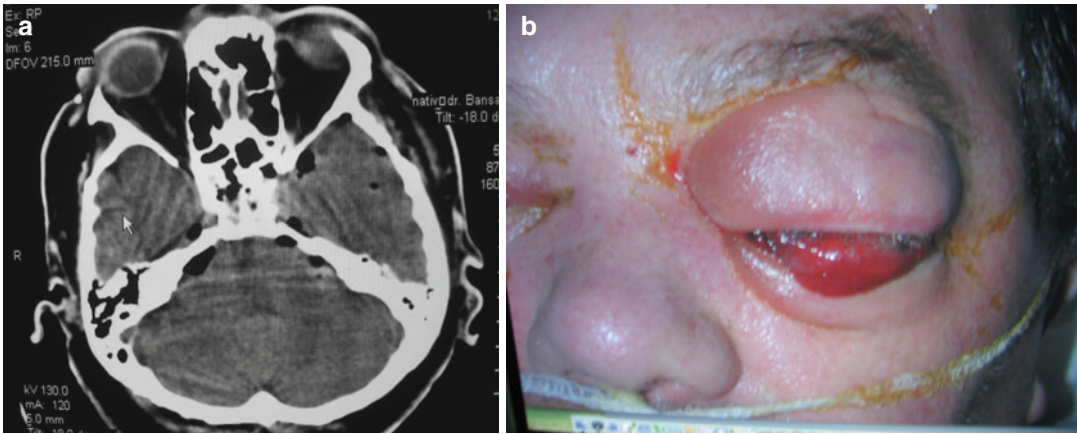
(a) CT image: A traumatic carotid–cavernous fistula developed in consequence of a basal skull fracture. (b) Characteristic swelling eyelid edema caused by the fistula, in serious phase of FCC the eyelids can barely be
